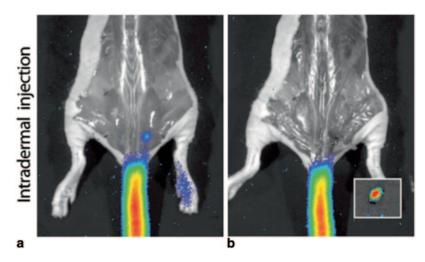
Cerenkov-guided surgical resection of sentinel lymph node, 10 min after intradermal injection of ¹⁸F-FDG into the tail with surgical resection. a Lateral-tail intradermal injection yields greater uptake in one sacral
